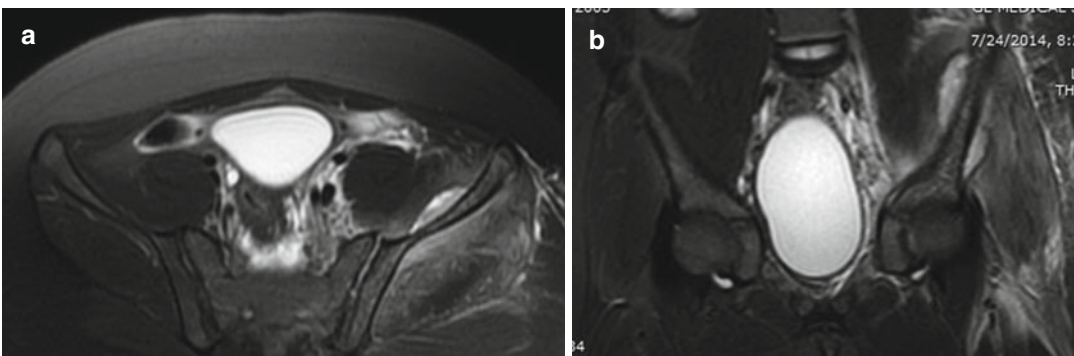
Osteomyelitis of the ilium with subperiosteal abscess and muscle myositis due to MRSA in a 13-year-old girl with a 5-day history of left hip pain, low-grade fever, and inability to bear weight. A plain pelvis radiograph was normal. MRI scans demonstrated the massive
